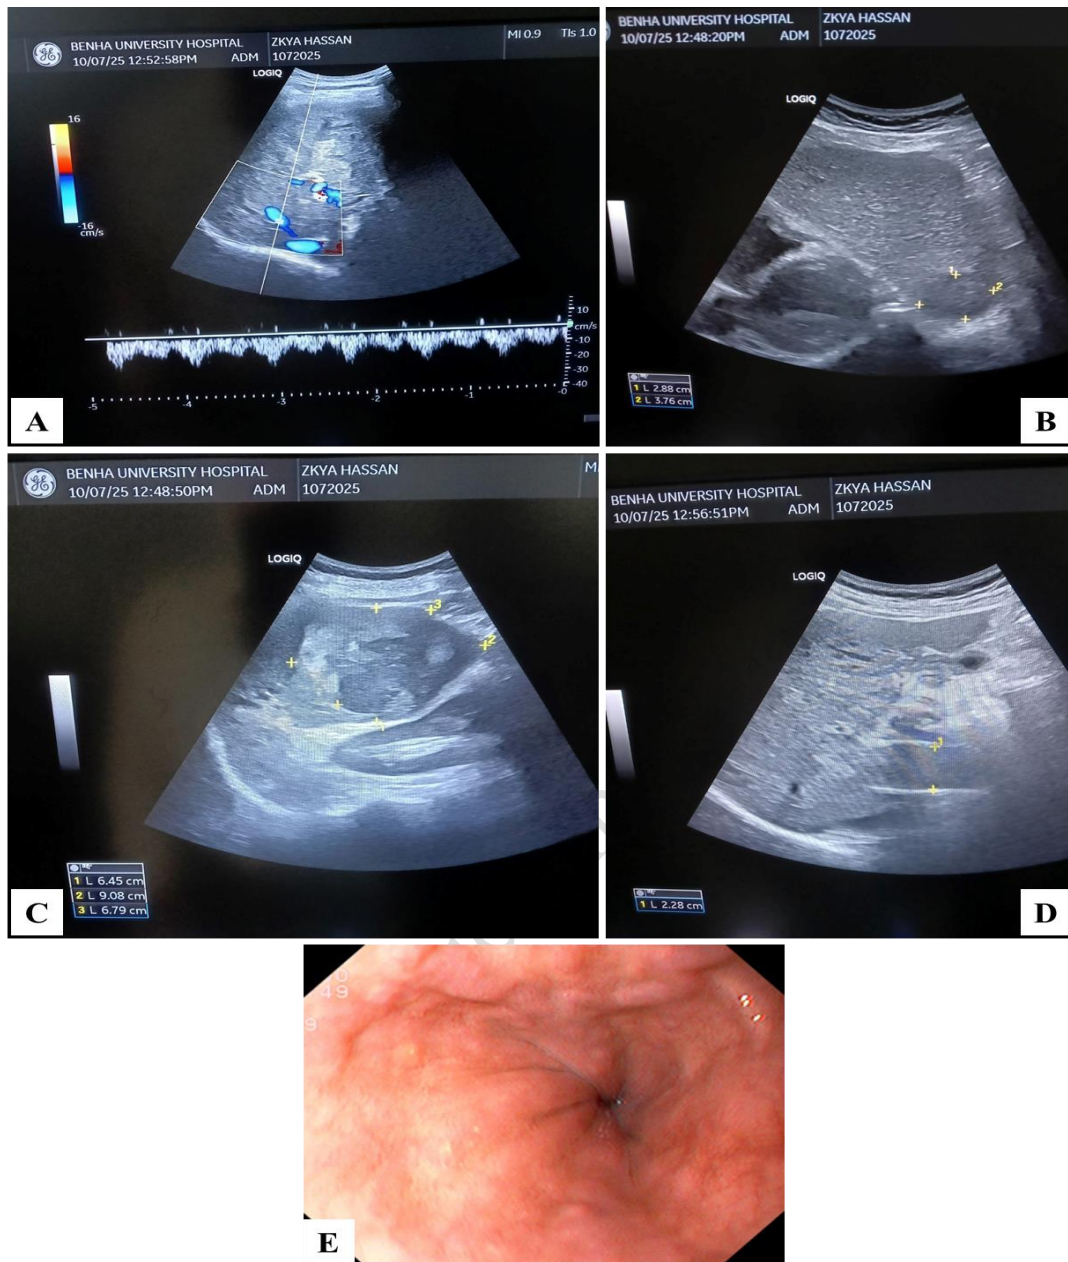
case 2: A 58-year-old male patient, not hypertensive or diabetic, with history of HCV, presented with abdominal pain. BMI: 19, Hb: 11.3 g/dL, INR: 1, platelet count: $262 \times 10^9/L$, creatinine: 0.8 mg/dL, Child-Pugh class A. A) Preserved hepatic venous Doppler (triphasic wave pattern). B,C) cirrhotic liver with bilobar hepatic focal lesions proven HCC. D) dilated malignant thrombosed PV, PVFV= zero with PV caliber measuring about 2.28cm. E) Upper GI Endoscopy Findings: four cords OV grade I. Agreement between DUS and Upper GI Endoscopy finding= low PVFV consistent with presence of OV with triphasic hepatic venous wave consistent with low grade OV.
